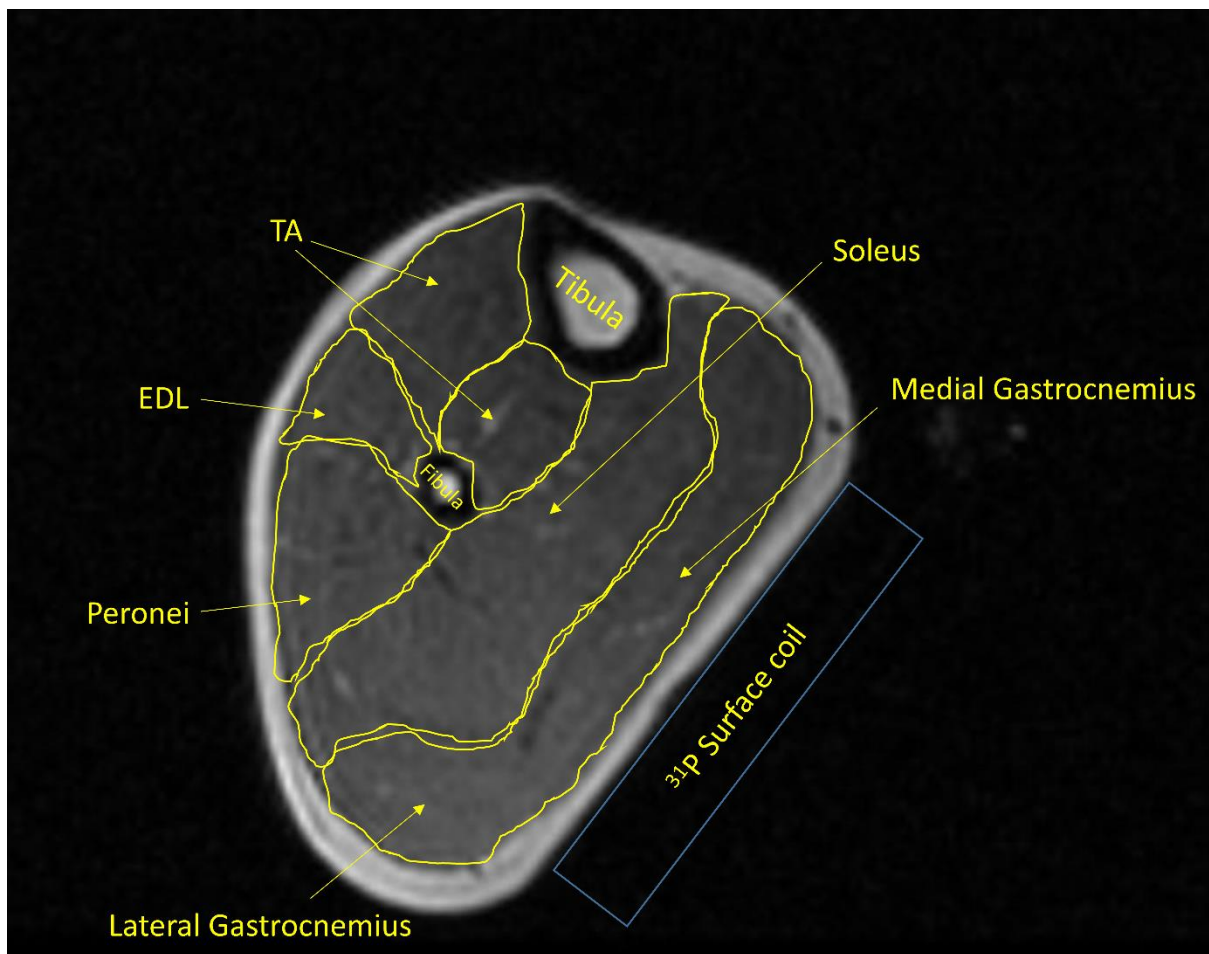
^1H MRI of human calf muscle in the axial plane demonstrating position of the ^{31}P surface coil relative to calf anatomy.
